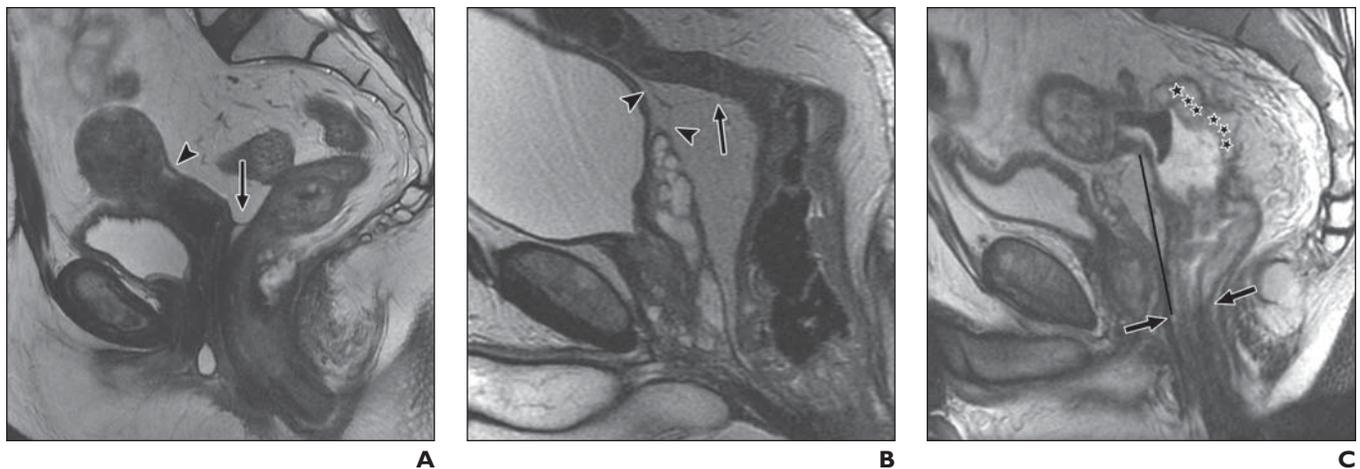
Sagittal T2-weighted rectal MRI showing anterior peritoneal reflection in different patients.
